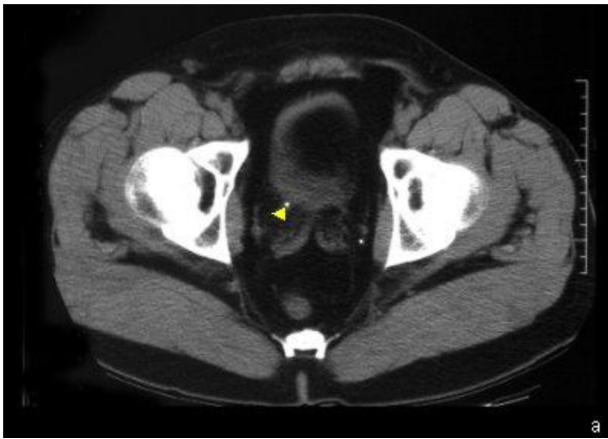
Ureteral stone/unenhanced CT scan shows stone distal ureter.
